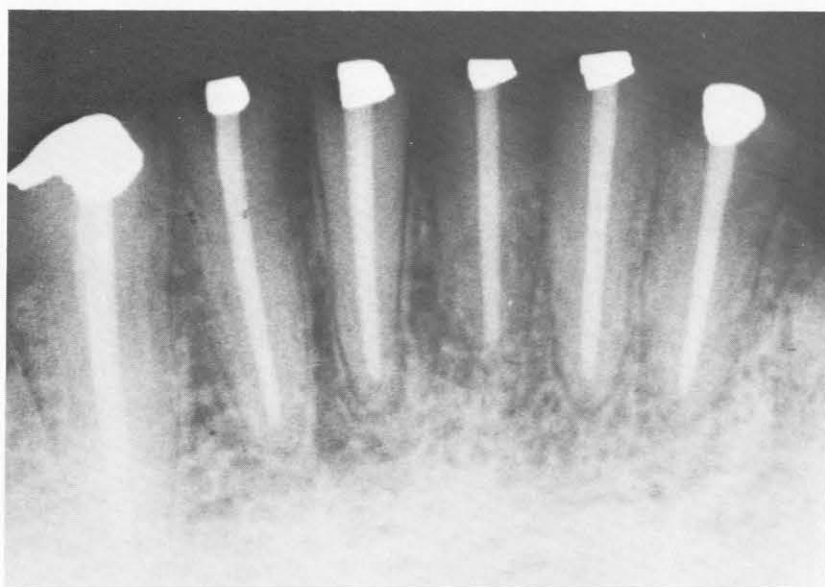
Followup radiograph, 6 years, 7 months
